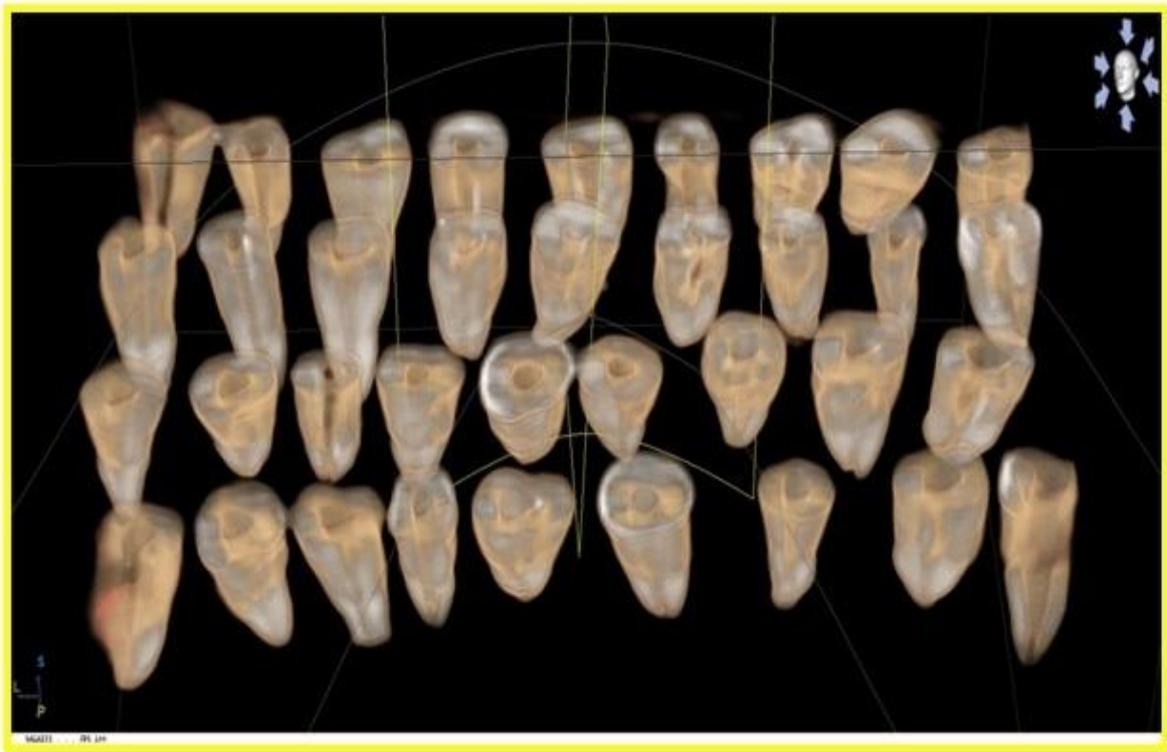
3-Dimensional Cone Beam Computed Tomography (CBCT) image after Retreatment.
